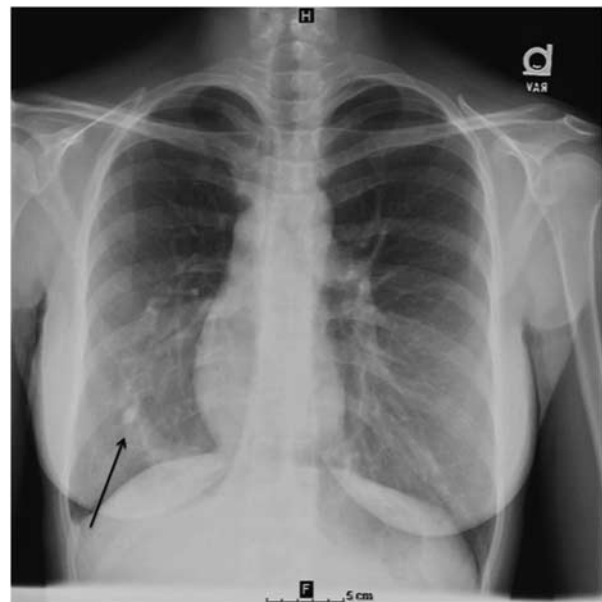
Initial chest X-ray. Chest X-ray showing the curvilinear density in the lower right chest consistent with a scimitar vein (arrow).
